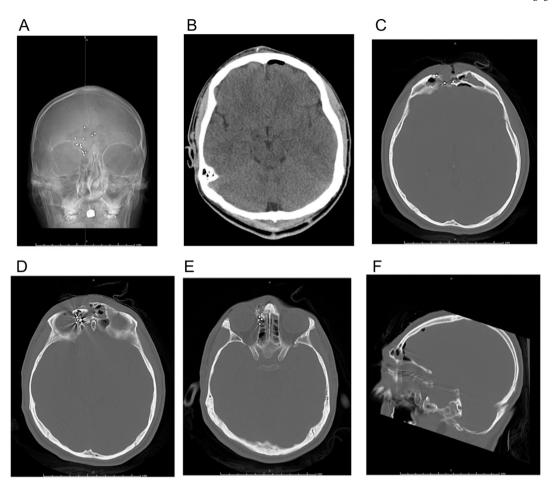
A (coronal), 3B, 3C, 3D, 3E (axial), and 3F (sagittal) show the CT Head without contrast of a 21 year-old-male who was evading the police and shot in the head with a beanbag. Finding shows comminuted frontal calvarial fractures with metallic fragments extending into the right and left orbits, as well as lamina papyracea and bilateral nasal bones. Small pockets of pneumocephalus are also visible.
